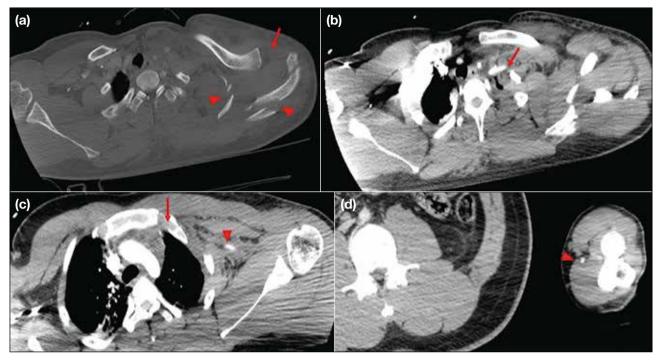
(a) Initial trauma computed tomography in bone window setting revealed diastasis of the left acromioclavicular joint (red arrow) and fracture of the left scapular body and acromion process (red arrowheads). (b) Computed tomography angiogram of left upper limb showing abrupt attenuation (red arrow) with a short segment of non-opacification of the left subclavian artery. At a more inferior level (c), there is preserved enhancement more distally (red arrowhead). The left sternoclavicular joint is normal (red arrow). At the level of the left proximal forearm on the delayed image (d), there is faint but delayed enhancement of the left brachial artery that is narrow in calibre (red arrowhead).
